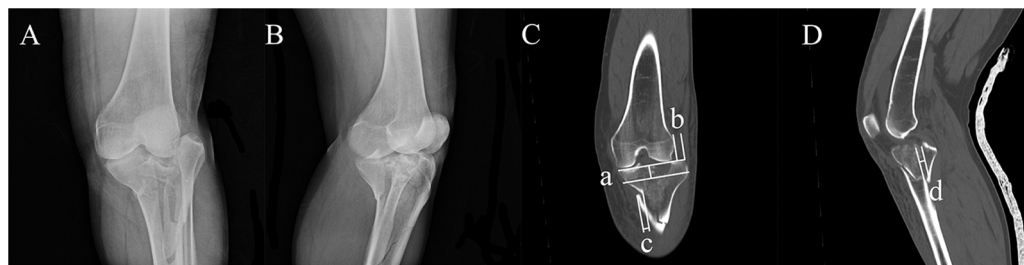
A 54 year-old male sustained left tibial plateau fracture in a traffic accident. (A) anterior-posterior view of the plain film (B) lateral view of the plain film (C) coronal view of the CT scan (D) sagittal view of the CT scan; a = lateral tibial plateau depression; b = lateral tibial plateau widening; c = medial tibial plateau displacement in coronal plane; d = medial tibial plateau displacement in sagittal plane; no medial tibial plateau depression in this case.
